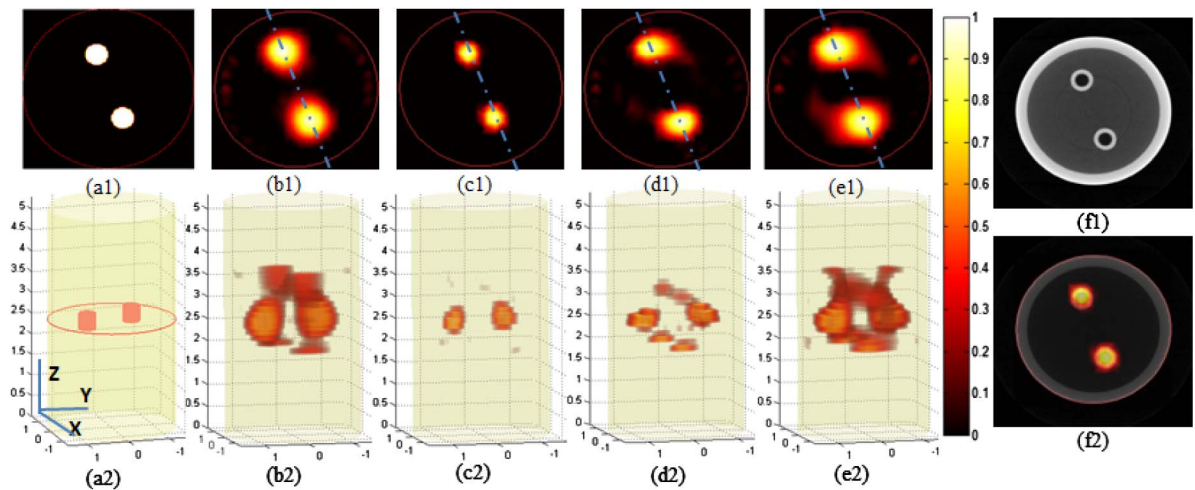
Reconstruction results. (a1) True cross section in the $z = 26$ mm plane, (a2) 3D rendering of true fluorescent targets. Slice (b1) and stereo (b2) are the reconstructed results obtained from L1-NCG-100. Slice (c1) and stereo (c2) correspond to re-L1-NCG algorithm. Slice (d1) and stereo (d2) correspond to L1-NCG-1000. Slice (e1) and stereo (e2) correspond to Tikhonov algorithm. (f1) The transverse section of CT image in $z = 26$ mm plane. (f2) The transverse overlay of (c1) and (f1).
